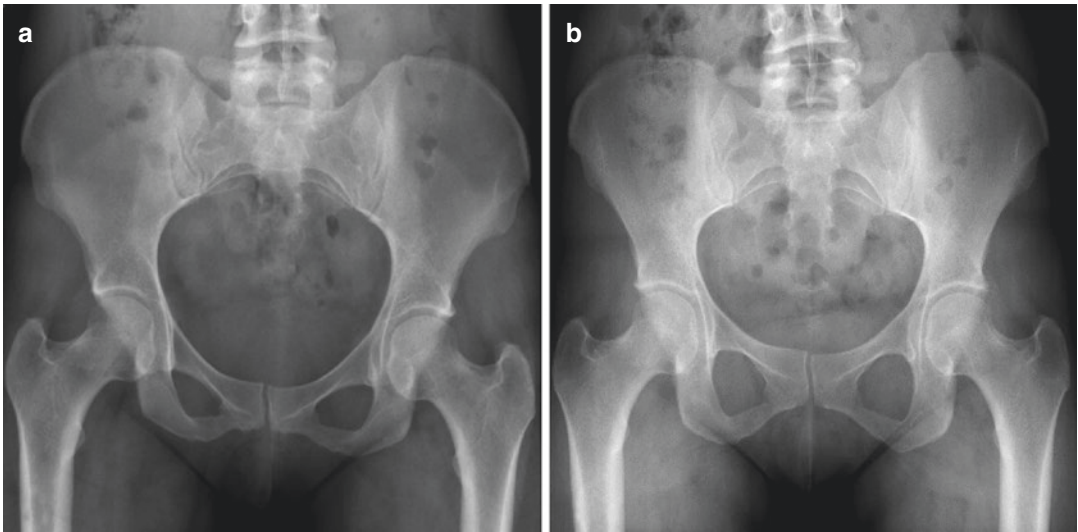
(a, b) AP radiographs of the pelvis obtained in the (a) supine and (b) weight-bearing positions in the same patient. In B the sacrum becomes more vertical and anterior acetabular coverage is reduced. Proper positioning on an AP pelvic radiograph is recognized when: (1) femur—
